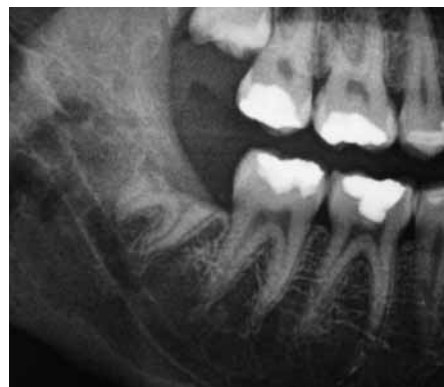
(a,b) – Case 2. Preoperative panoramic radiography and dental CT: intimate relationship between right mandibular third molar and the mandibular canal.
